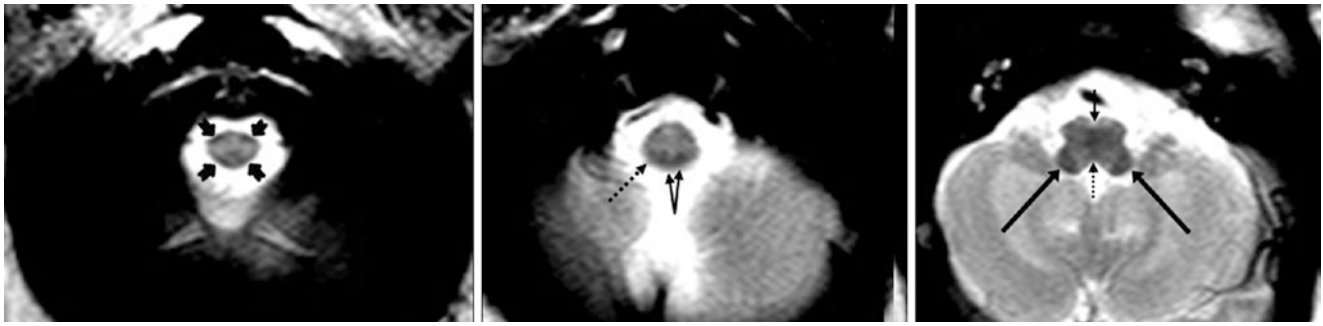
A 21-day-old term neonate had a normal 3T MRI with SE T2WI. There were mildly dark ICP (*long arrows*), PD (*tiny arrow*), and right STV (*dotted arrows*), along with gracile fasciculi (*split arrows*).
